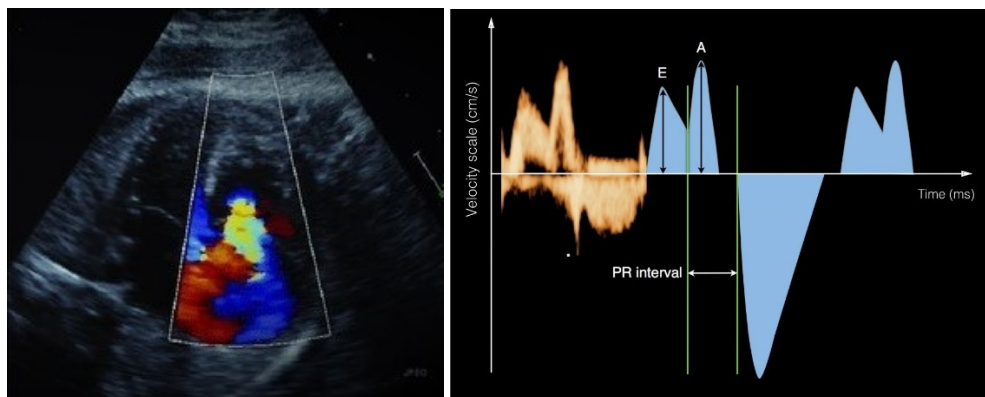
Fetal echocardiogram showing a) The four-chamber ultrasound image with the color flow Doppler [29] - left; b) The pulsed Doppler waveform measured across atrioventricular valves with marked peaks E and A [28] - right
